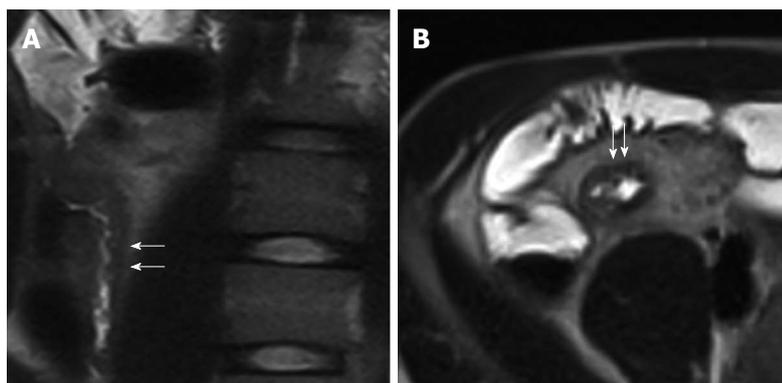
Coronal (A), transverse (B) T2-weighted images show thickened, inflamed segments of the terminal ileum with deep ulcers seen as high-contrast protrusions within bowel wall (arrows).
